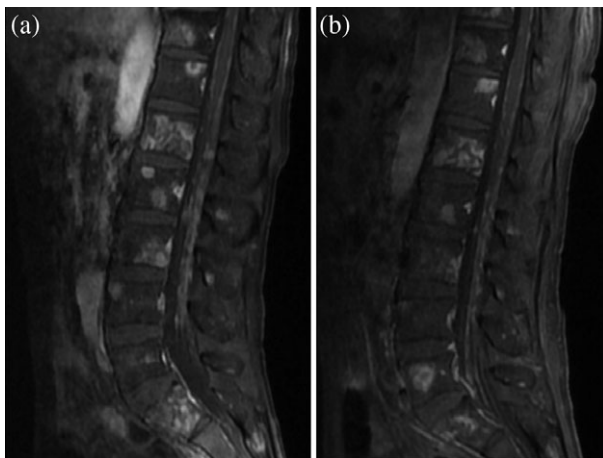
Sagittal sections of contrast-enhanced magnetic resonance imaging (MRI) of the lumbar spinal cord (a) before and (b) after ceritinib treatment. (a) Multiple intradural extramedullary nodules with abnormal enhancement were observed before ceritinib treatment. (b) The multiple intradural extramedullary nodules improved after ceritinib treatment.
